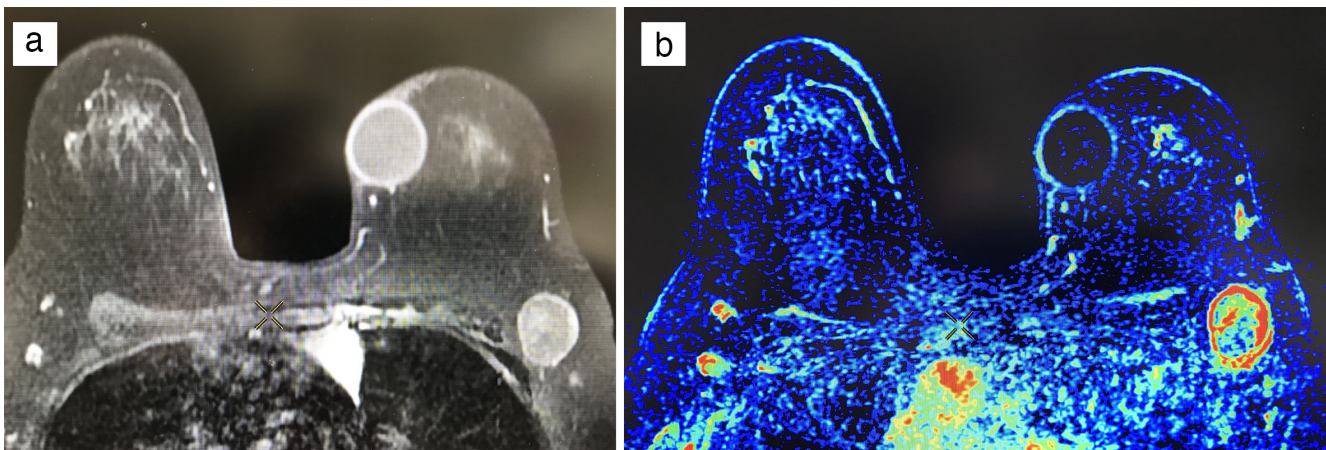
Dynamic contrast-enhanced magnetic resonance imaging examination of the same patient mentioned in Figure 1. (a) Contrast enhanced fat-suppressed T1-weighted axial image shows peripherally enhanced, round shaped left axillary lymph node with diameter of 38 × 22 mm. (b) Postcontrast subtracted axial image emphasizes rim-like contrast enhancement
